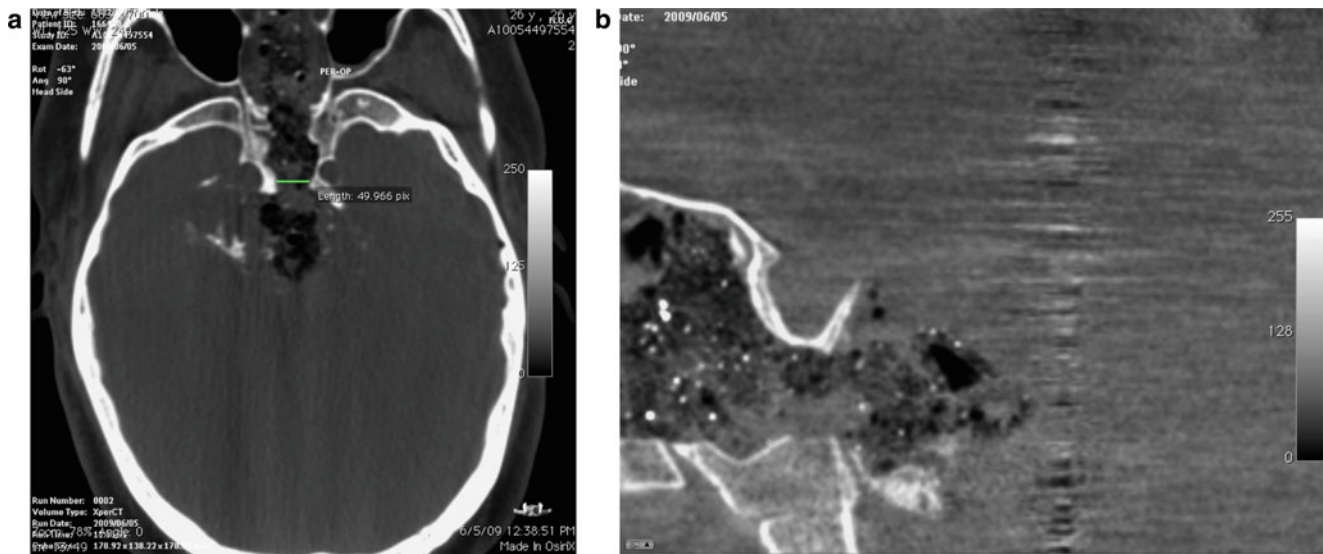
Intra-operative CT-images, obtained with Flat Panel system, for resection control in case of large calcified clival chordoma, which was approached via the sublabial transsphenoidal route. Remnants of the calcified tumour can still be appreciated on axial images (a), as well as inferiorly on sagittal reconstructions (b)
